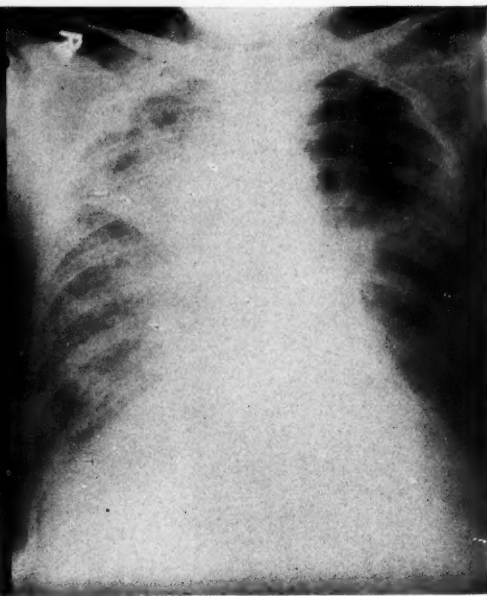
Case 4. Same patient as Figure 5. Increase in degree of involvement despite X-ray treatment and temporary relief of symptoms. Left chest now shows definite involvement. Interval, approximately two months.
